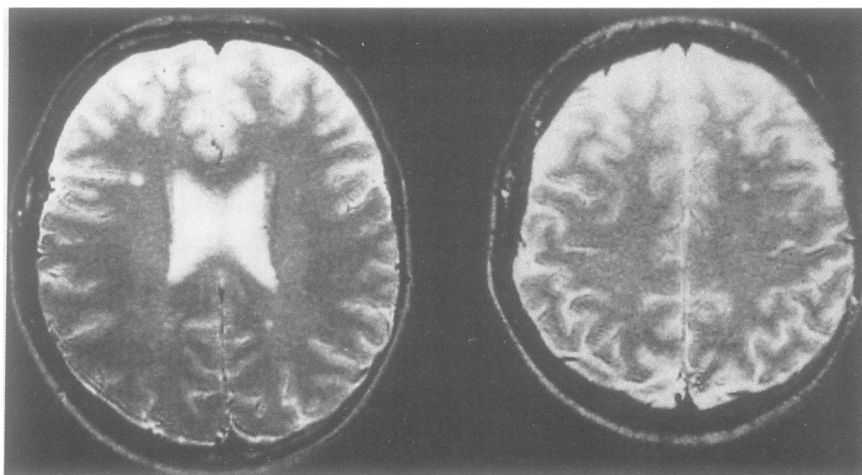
Hyperintense lesions on T2-weighted MRI in a 25 year old female physician without history or signs of a neurological disorder who was investigated as a control subject.
